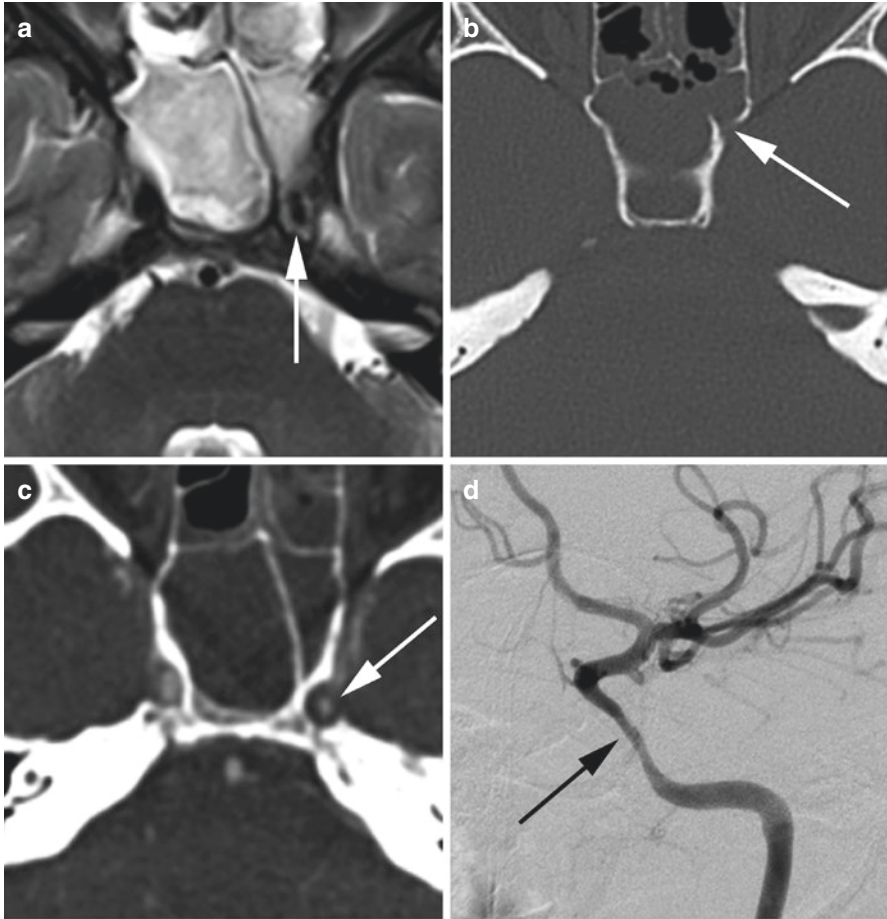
Cavernous internal carotid artery perivascular spread of infection. Patient presenting with headache was evaluated initially with a noncontrast MRI. MRI T2-weighted images (a) showed completely opacified sphenoid sinuses and adjacent narrowing of the left cavernous ICA flow void (arrow). CT bone algorithm (b) showed dehiscence along the left sphenoid sinus (arrow) with adjacent narrowing of the left cavernous ICA on CTA (c, arrow). DSA (d) confirmed fusiform narrowing of the left cavernous ICA (arrow). Further testing revealed fusibacterium necrophorum infection of the sphenoid sinuses
